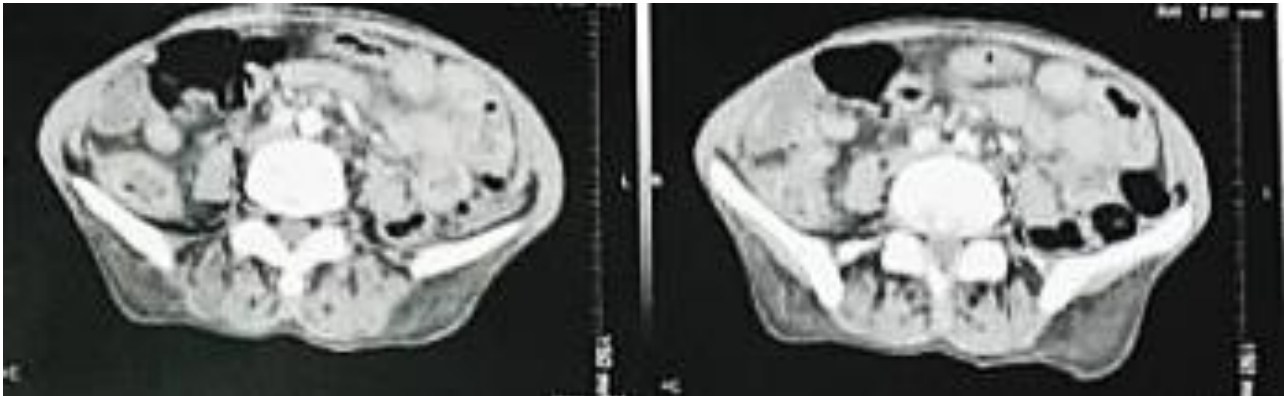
Axial section abdominal CT scan objectifying a stepwise multifocal digestive parietal thickening
